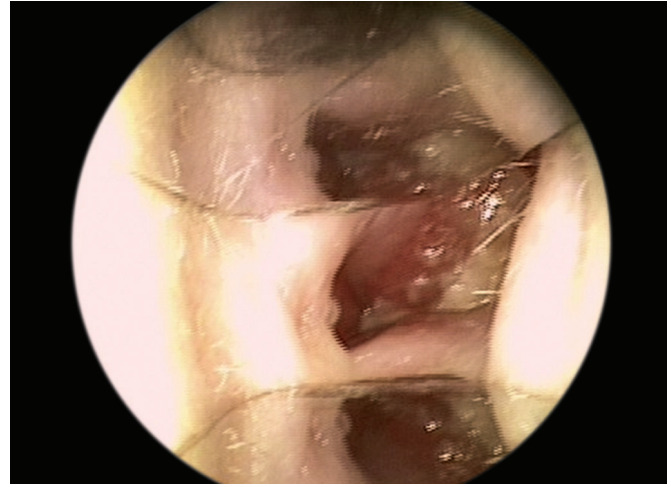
Intranasal image of glioma seen on magnetic resonance image.
